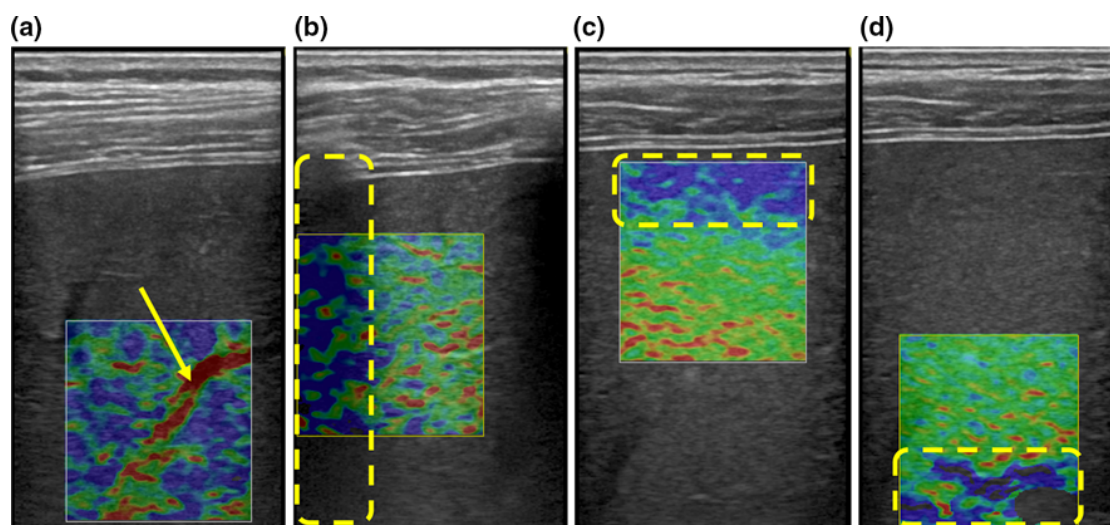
RTE image artifacts. Large blood vessel (a), acoustic shadow (b), multiple reflection echo (c), and poor ultrasound penetration (d) are major artifacts of RTE. For RTE, these artifacts should be avoided [12]
